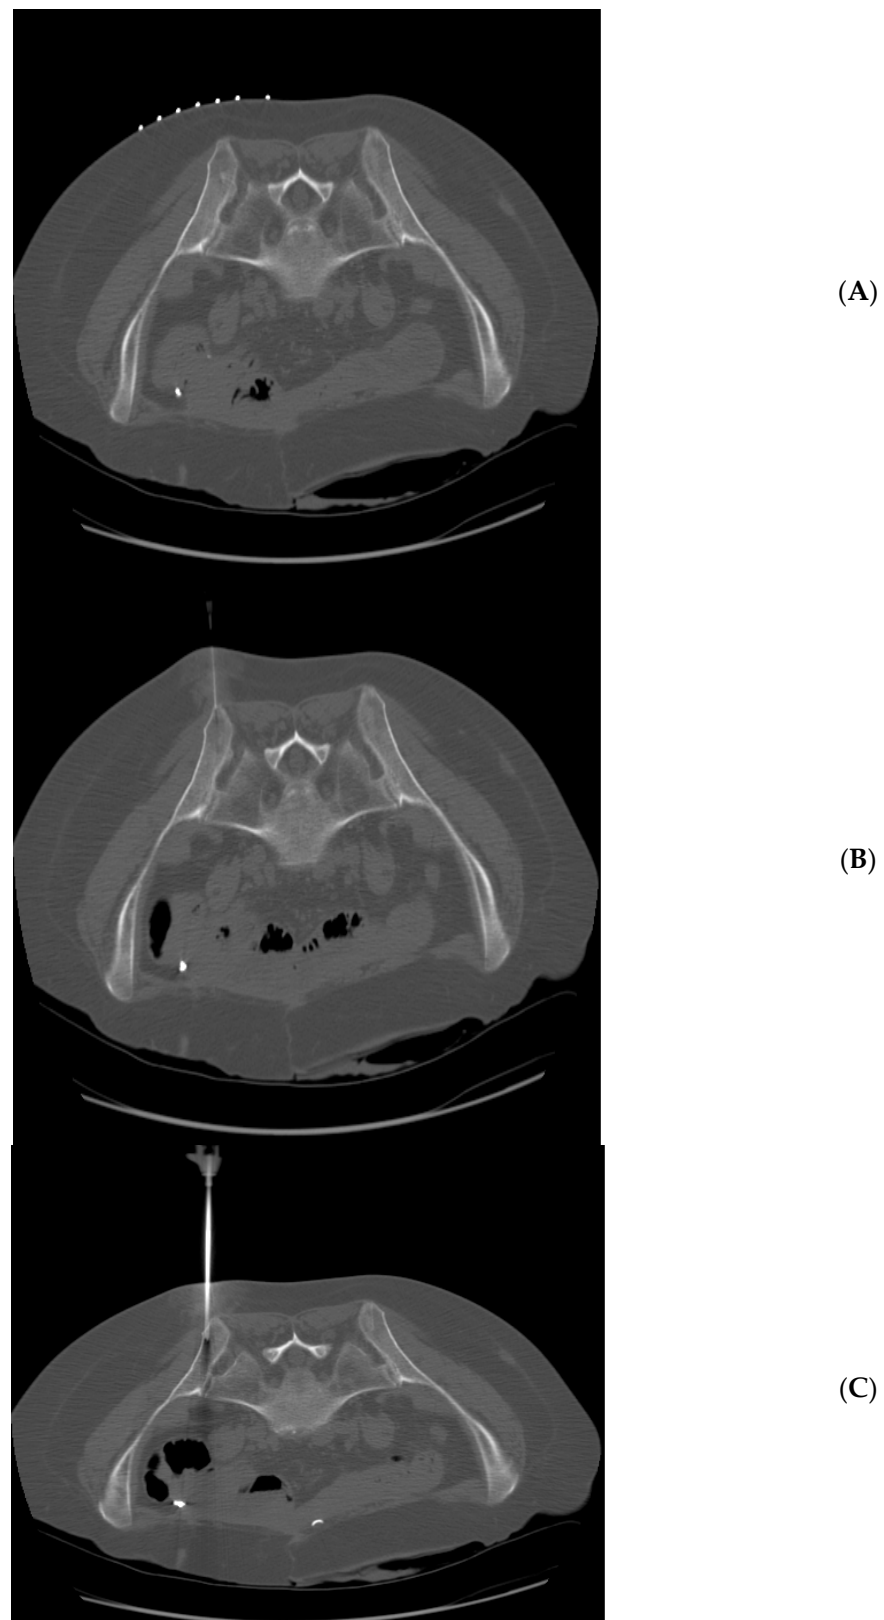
71 year-old woman with acute myeloid leukemia. Technically successful biopsy, but insufficient pathologic diagnosis. (A) Prone position pre-planning CT with skin guidance markers on the right side of the patient. (B) Prone position CT with biopsy needle tip approaching right posterior iliac spine. (C) Prone position CT with biopsy needle tip within the right posterior iliac spine.
